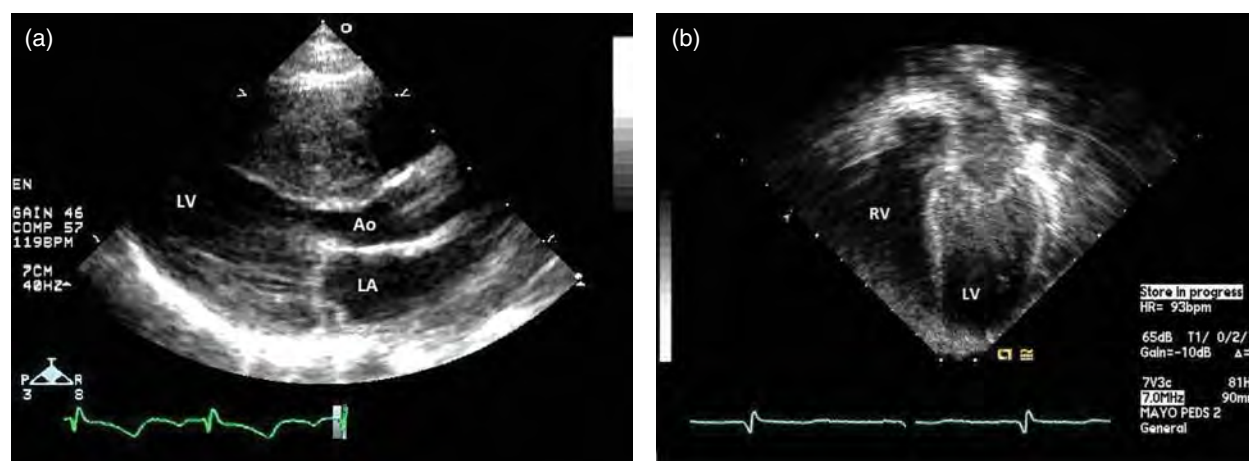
Echocardiogram of patient with non-syndromic, idiopathic left ventricular hypertrophy (LVH; i.e., hypertrophic cardiomyopathy, HCM). (a) Parasternal long-axis and (b) apical four-chamber views of patient with early onset HCM demonstrating severe concentric hypertrophy, thickened mitral valves, and hypertrophied papillary muscles. Ao, aorta; LA, left atrium; LV, left ventricle; RV, right ventricle.
